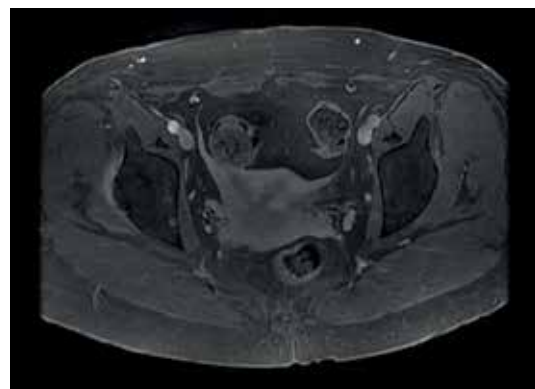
Preoperative MRI showing septate uterus with a smooth uterine fundus.
